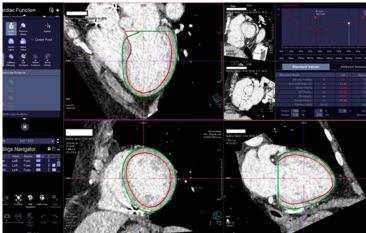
We intend to increase contrast in the CT-image in order to improve on the segmentation of the left ventricle, which will be used to calculate volume, LVEF and circumferential and longitudinal strain in the left ventricle.
